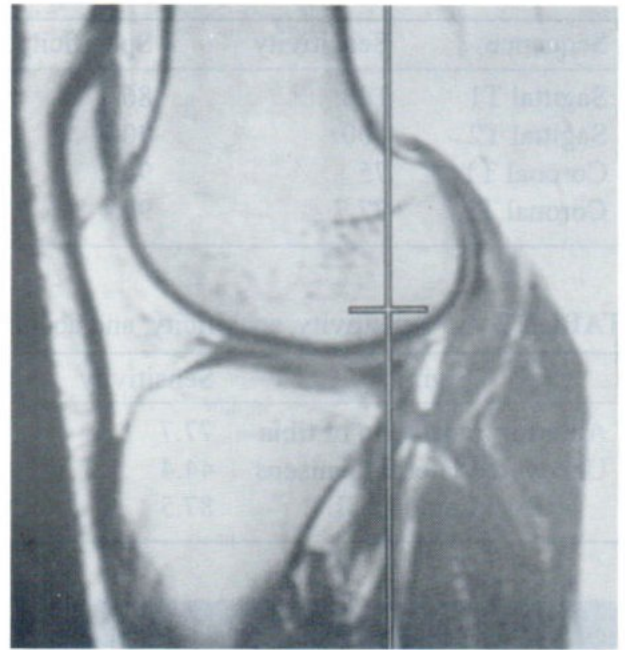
Positive uncovered lateral meniscus sign. On sagittal T1-weighted MR image, the vertical line drawn tangent to the posteriormost cortical margin of lateral tibial plateau intersects the posterior horn of lateral meniscus.
